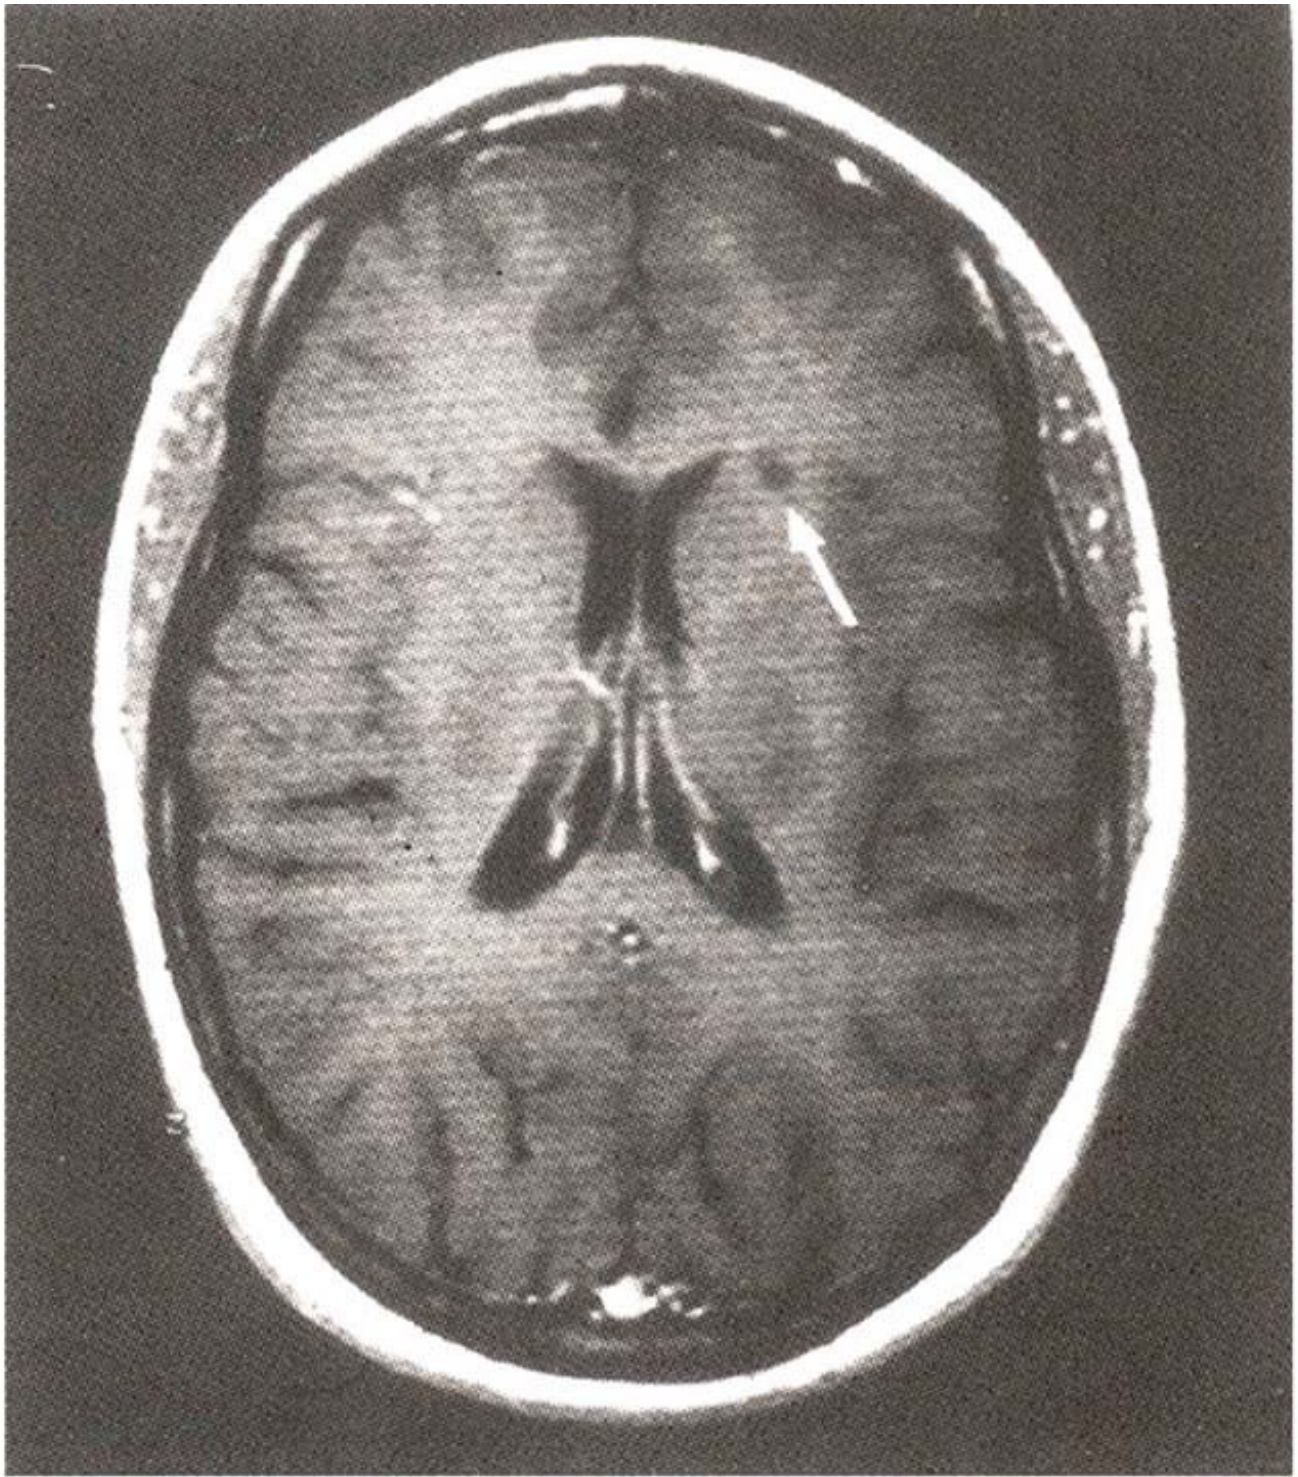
Two weeks later, brain MRI reveals considerably diminished signal intensity (arrow) without any enhancement (arrow).
